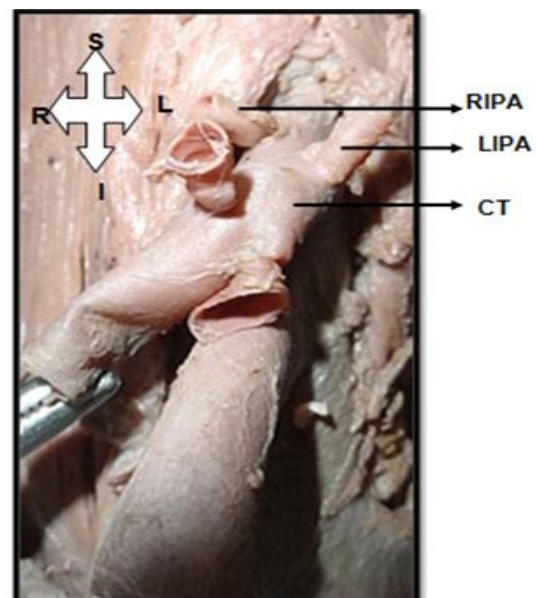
Origin of LIPA from CT and RIPA from AA.
